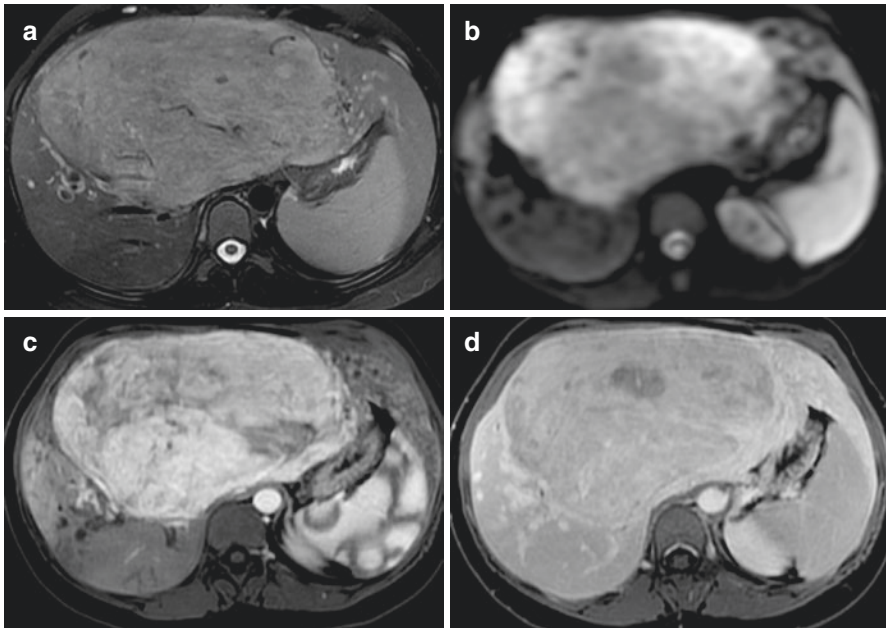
MR imaging of a typical large hemangioma in a 48-year-old woman. (a, b) The lesion shows nodular peripheral enhancement on post-contrast arterial phase images with progressive enhancement on portal venous phase images. On diffusion-weighted images ( $b = 800$ ), the lesion shows high signal intensity (c) and a high ADC value (d) corresponding to a “T2-shine-through” effect
